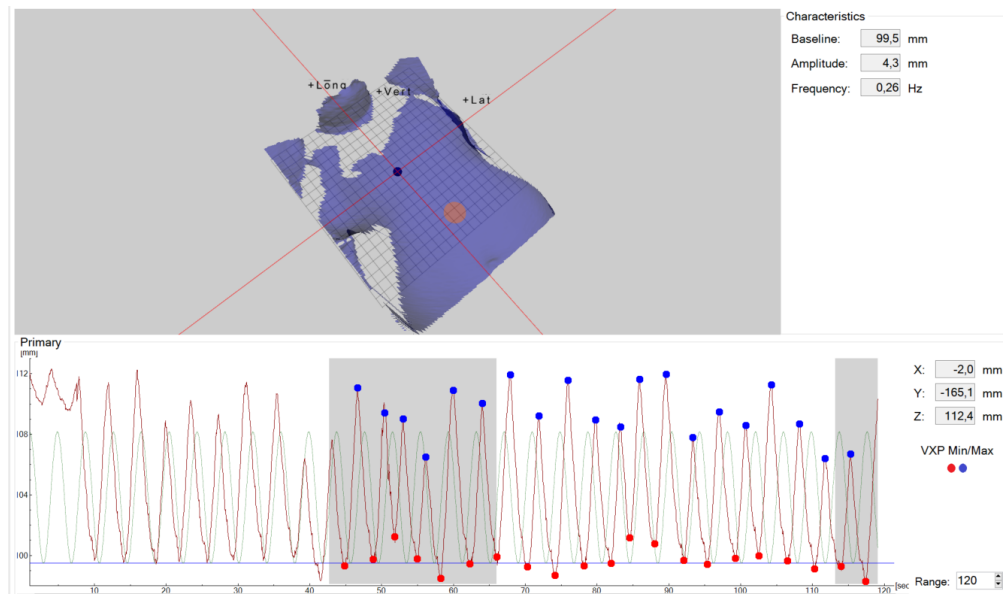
An example of a monitored breathing curve (bottom graph) and surface scan (top image) from the Sentinel system. The red dot on the patient surface (top image) marks the region of interest (ROI) that acquires the breathing motion. Blue and red markers in the breathing motion (bottom graph) marks inhale and exhale maxima respectively. Gray area represents where recording of the breathing motion is enabled, i.e. connection of the Sentinel system and the CT-scanner, and the white area between the gray intervals represents the breathing motion that was recorded during 4-dimensional computed tomography (4DCT) acquisition.
